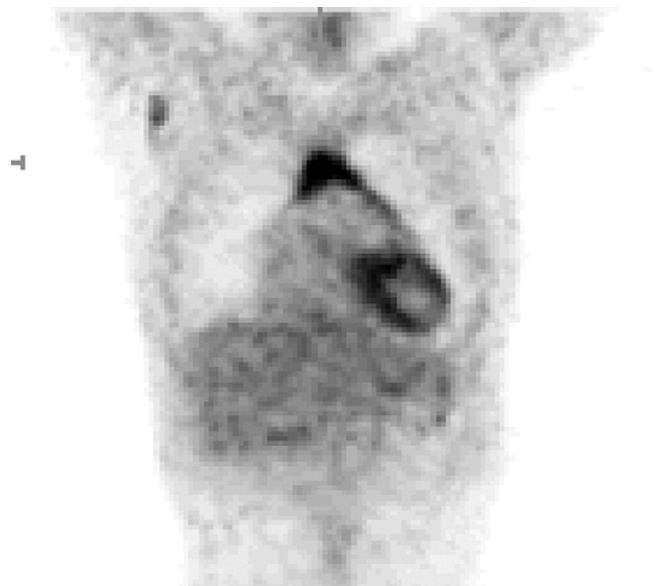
Coronal PET image of 15-year-old male reveals triangular shaped FDG uptake in normal thymus.
